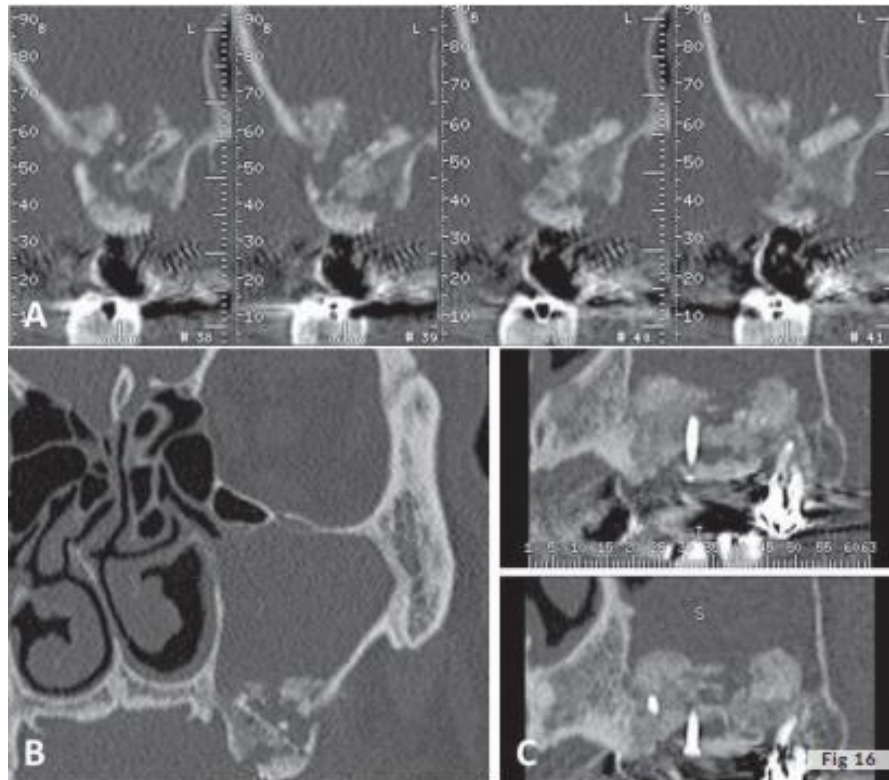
Left maxillary sinusitis on osteitis with graft necrosis; Dentascanner oblique coronal reconstructions (A), panoramic views (C) and coronal CT section (B): heterogeneous graft appearance reflecting graft osteitis complicated by left maxillary sinusitis . Adapted from (Tarragano Hervé et al., 2019)
